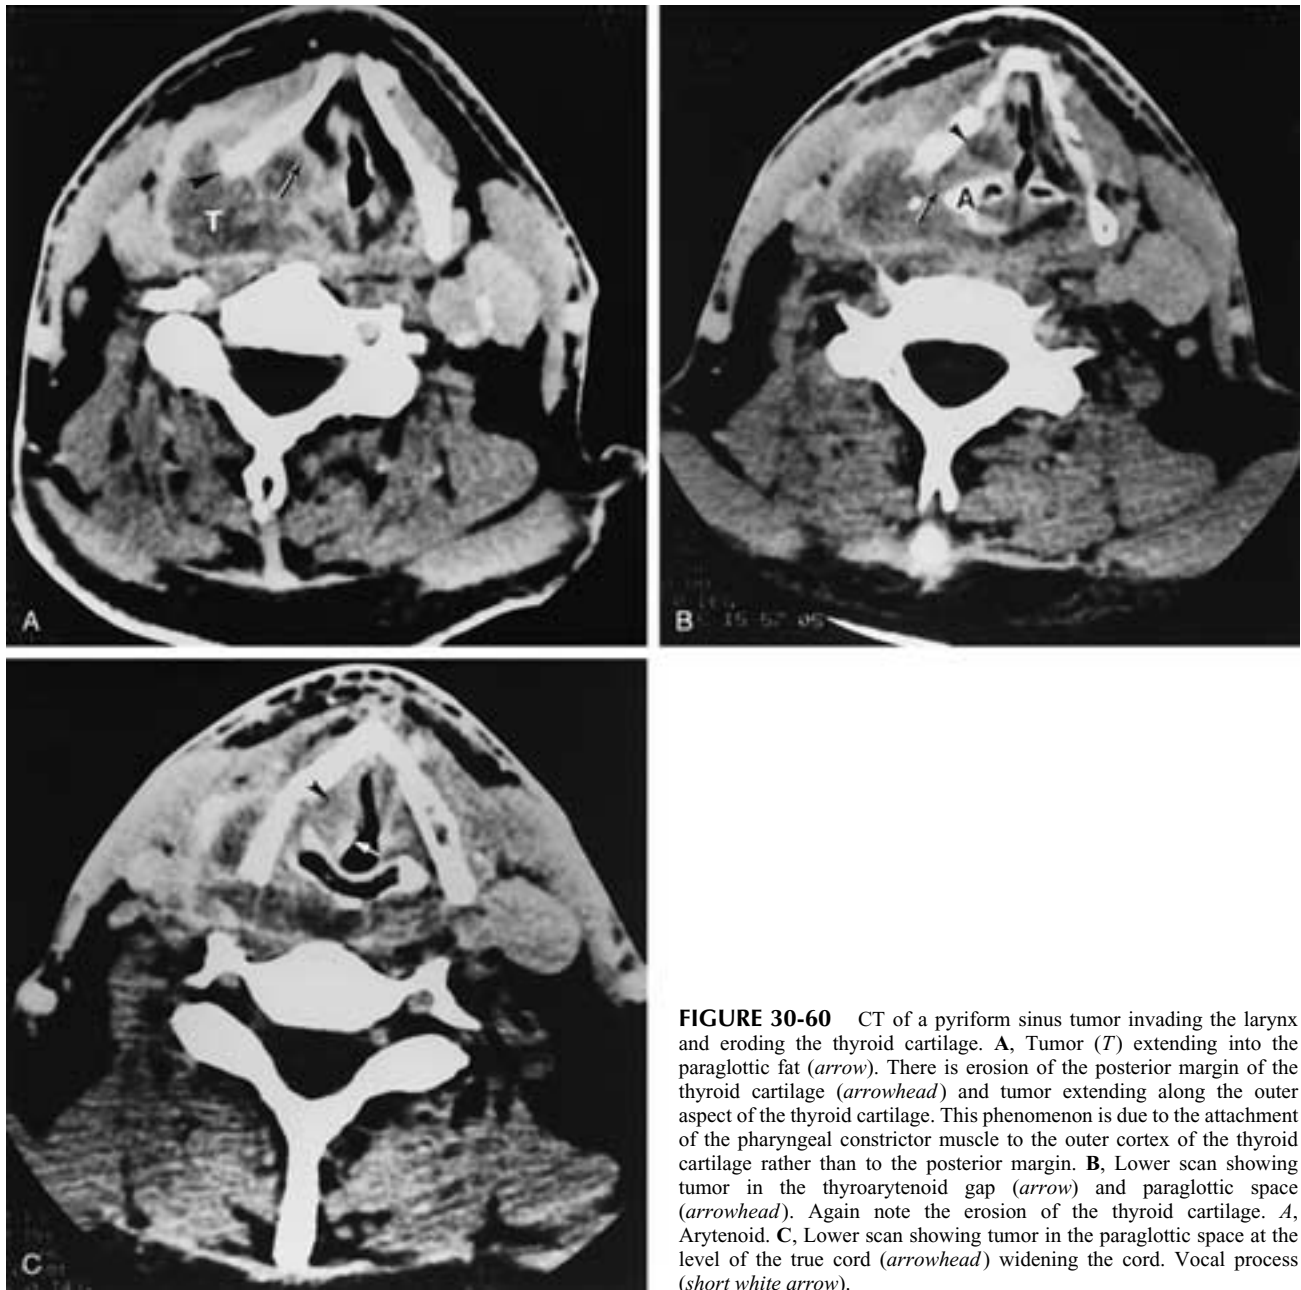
CT of a pyriform sinus tumor invading the larynx and eroding the thyroid cartilage. A, Tumor (*T*) extending into the paraglottic fat (*arrow*). There is erosion of the posterior margin of the thyroid cartilage (*arrowhead*) and tumor extending along the outer aspect of the thyroid cartilage. This phenomenon is due to the attachment of the pharyngeal constrictor muscle to the outer cortex of the thyroid cartilage rather than to the posterior margin. B, Lower scan showing tumor in the thyroarytenoid gap (*arrow*) and paraglottic space (*arrowhead*). Again note the erosion of the thyroid cartilage. *A*, Arytenoid. C, Lower scan showing tumor in the paraglottic space at the level of the true cord (*arrowhead*) widening the cord. Vocal process (*short white arrow*).
